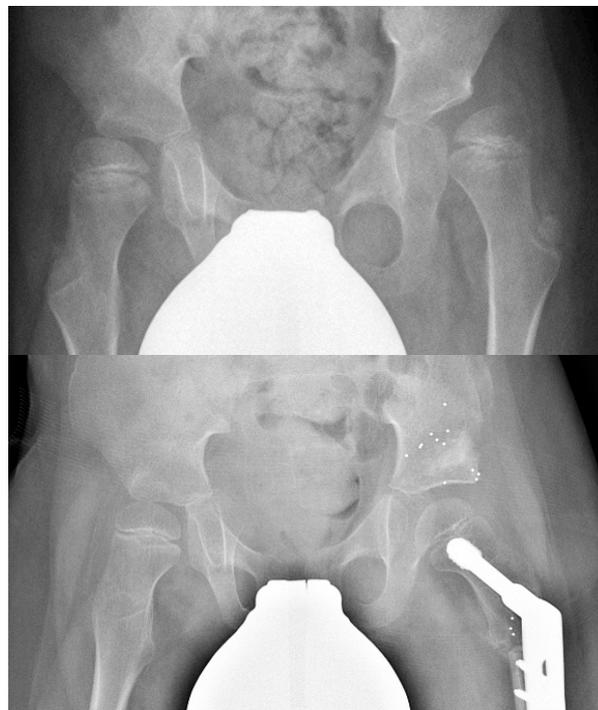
The figure shows the preoperative and six-month postoperative AP pelvic radiographs of a seven-year-old boy with severe left hip lateralization and acetabular dysplasia.
